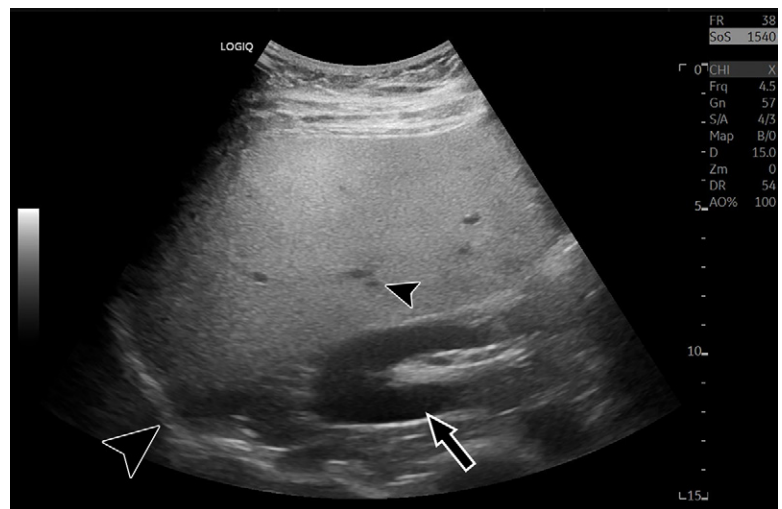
Characteristic B-mode US image in a 35-year-old male patient with hepatic steatosis and 16% MRI proton density fat fraction. Steatosis results in increased brightness of the liver relative to the kidney (arrow), blurring of hepatic vasculature (small arrowhead), loss of definition of the diaphragm (large arrowhead), and reduced signal from deep anatomy.
